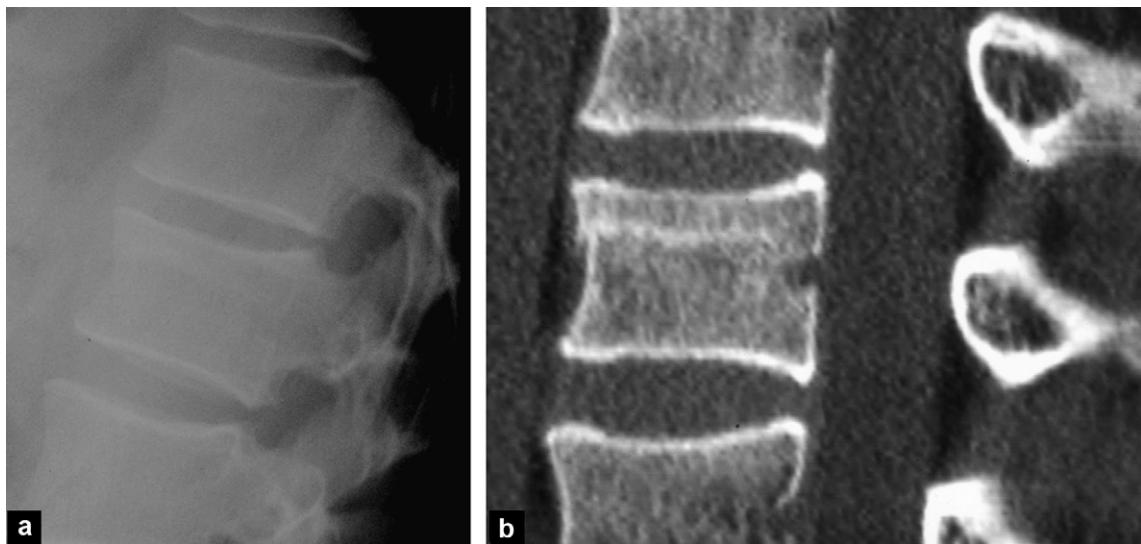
Compression fracture with endplate impaction. a: standard X-ray: compression of the upper plateau, the height of the posterior wall is respected. No anomaly of the posterior arch; b: CT (sagittal reformat): confirmation of a A1 type compression fracture.
